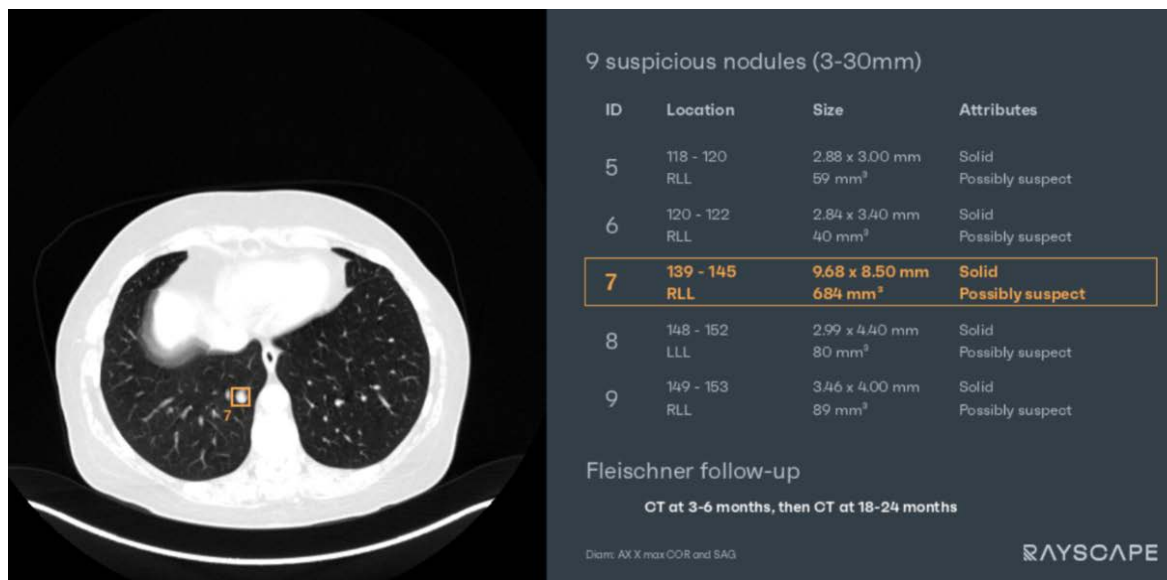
Data Report (AI-assisted detection and structured reporting of pulmonary nodules on chest CT). Axial chest CT image demonstrating automatic detection of a pulmonary nodule highlighted with a bounding box (left). The AI-generated interface (right) displays a structured list of detected nodules, including lesion ID (number), anatomical location (lung and lobe), size (diameter and volume), and imaging characteristics (e.g., solid appearance, suspicion level). The system also provides guideline-based follow-up recommendations according to Fleischner criteria, facilitating standardized clinical assessment.
